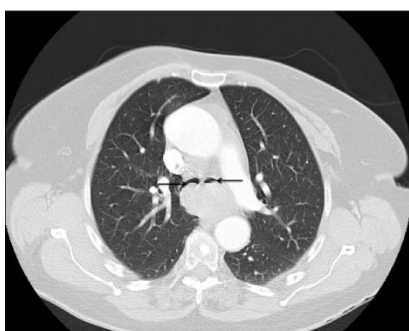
Preoperative computed tomography scan assessment of the thorax-case 2. Transverse plane showing the near complete obstruction of both main bronchus.
